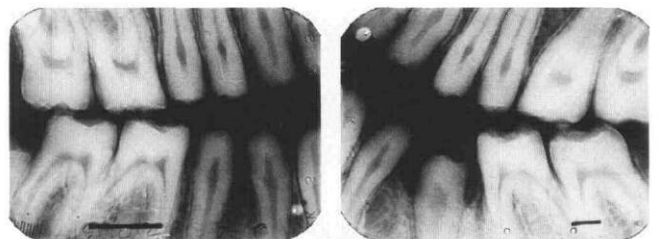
Bite-wing radiographs of patient in Fig 2a, showing thin enamel and spacing between the teeth.
